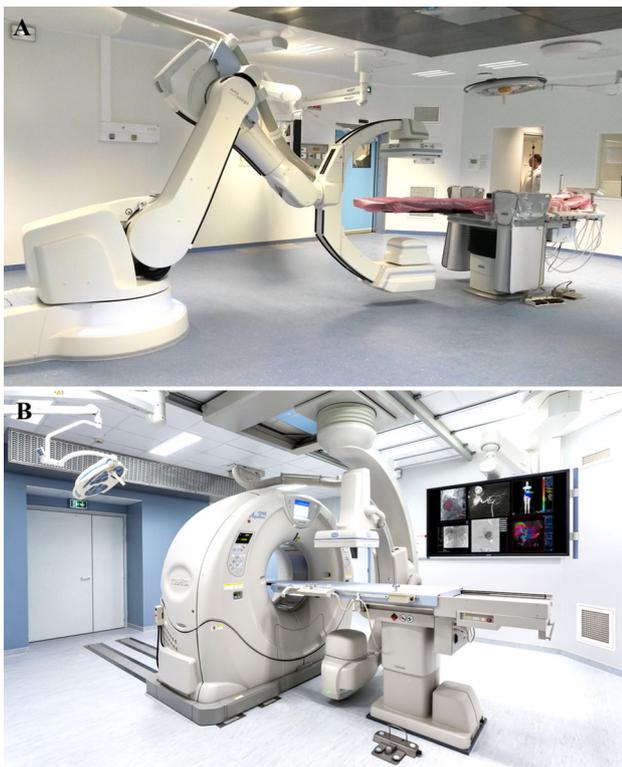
IR suite equipped with A Angio system with CBCT capability (*Artis Zeego*, Siemens Healthineers); B Angio-CT (*Infinix-i 4D CT*, Canon Medical Systems)
